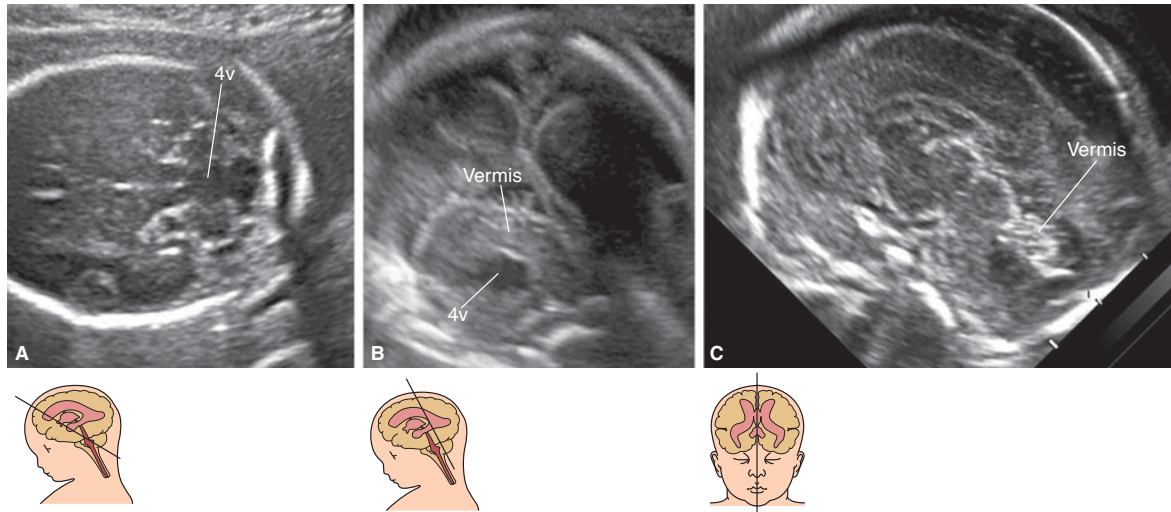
Sonography of vermian hypoplasia. The fourth ventricle (4v) is open; the vermis is present but is about half the normal size and does not demonstrate any of the typical anatomical landmarks, the fastigium point and the main fissures. The cisterna magna is not enlarged. Downslanting of the tentorium suggests a normal insertion of the torcular herophili (TH). (Reproduced, with permission, from *Atlas of Obstetric Ultrasound*, 2009. The Global Library of Women's Medicine. www.glowm.com.)
